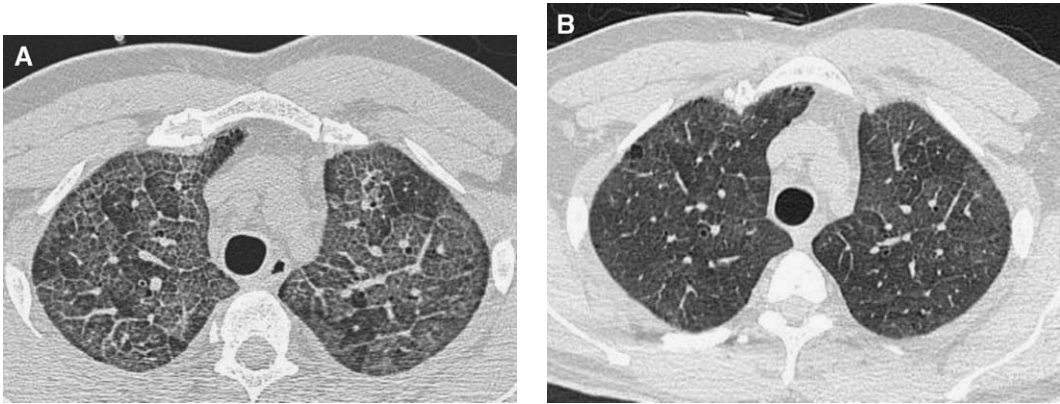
CT scan of viral pneumonia before (A) and after (B) antiviral treatment.
